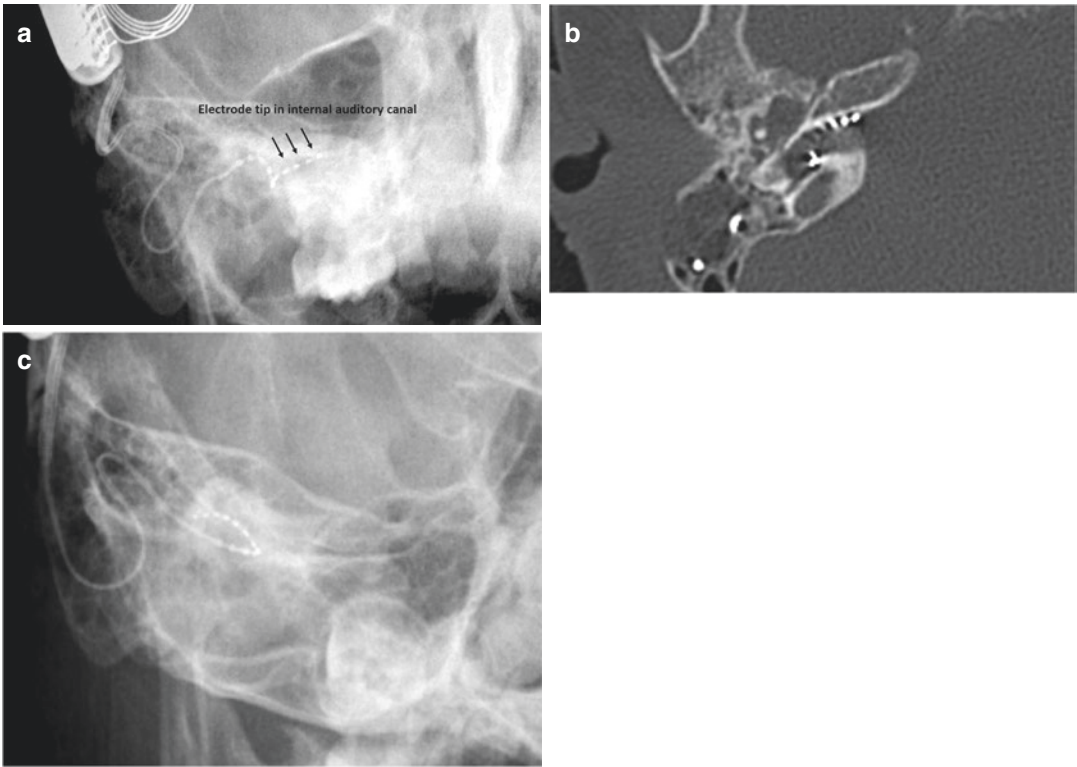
Postoperative imaging demonstrating electrode migration into IAC: (a) transorbital X-ray, (b) CT findings, (c) repositioned electrode after double labyrinthotomy
